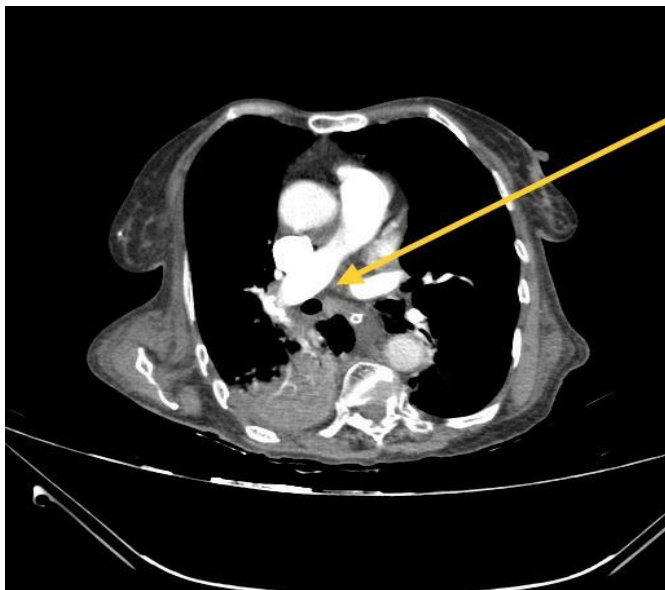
CT Pulmonary Angiography showing Thrombus in Right pulmonary artery (Yellow arrow)
